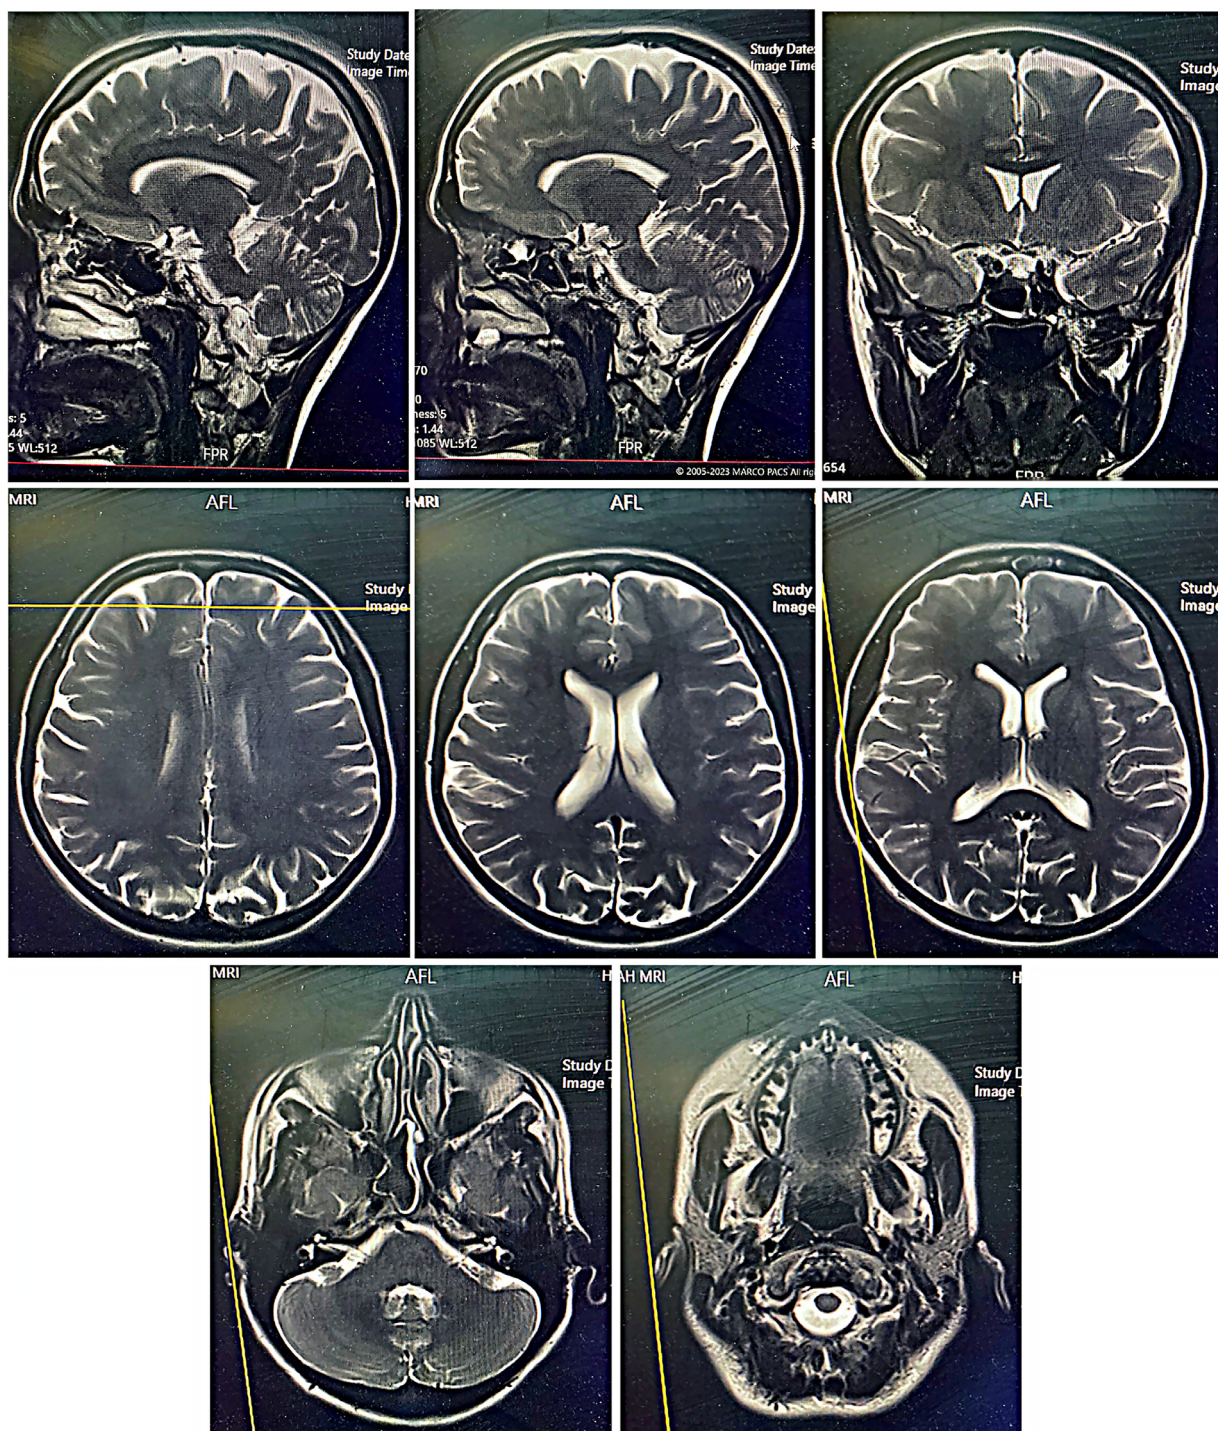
Magnetic resonance imaging showed no pathological lesions.
